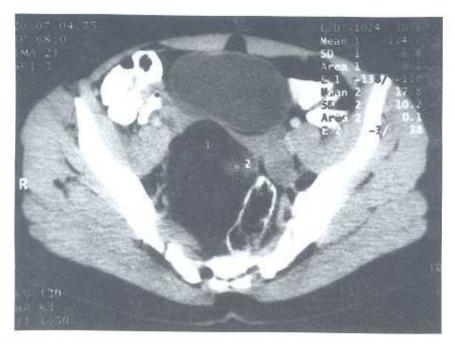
CT of an ovarian dermoid cyst with fatty content and mural solid nodule. Very low density measured in the cyst is consistent with fat.
